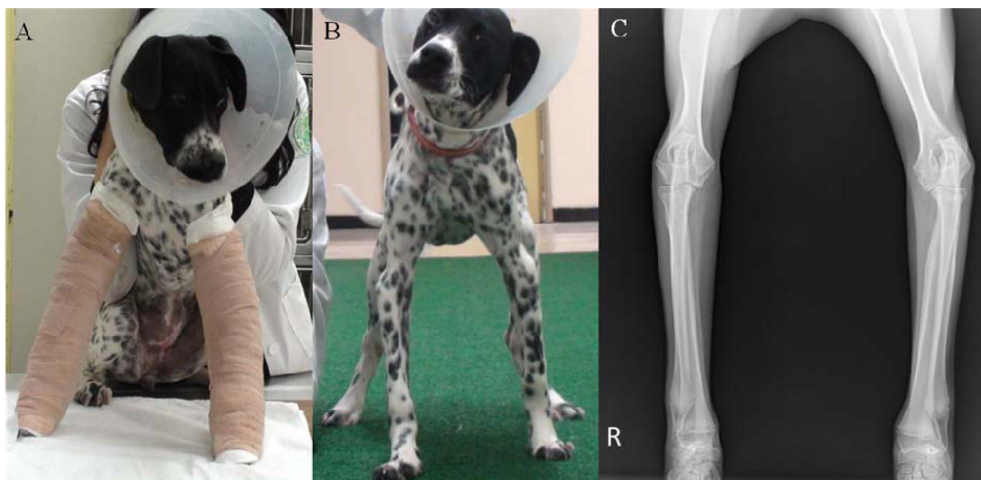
Posture after bilateral application of the modified Robert-Jones bandage (A). After 3 weeks of treatment, normal posture and gait with weight bearing was observed (B). Non-remarkable findings were observed on radiographic examination (C).
